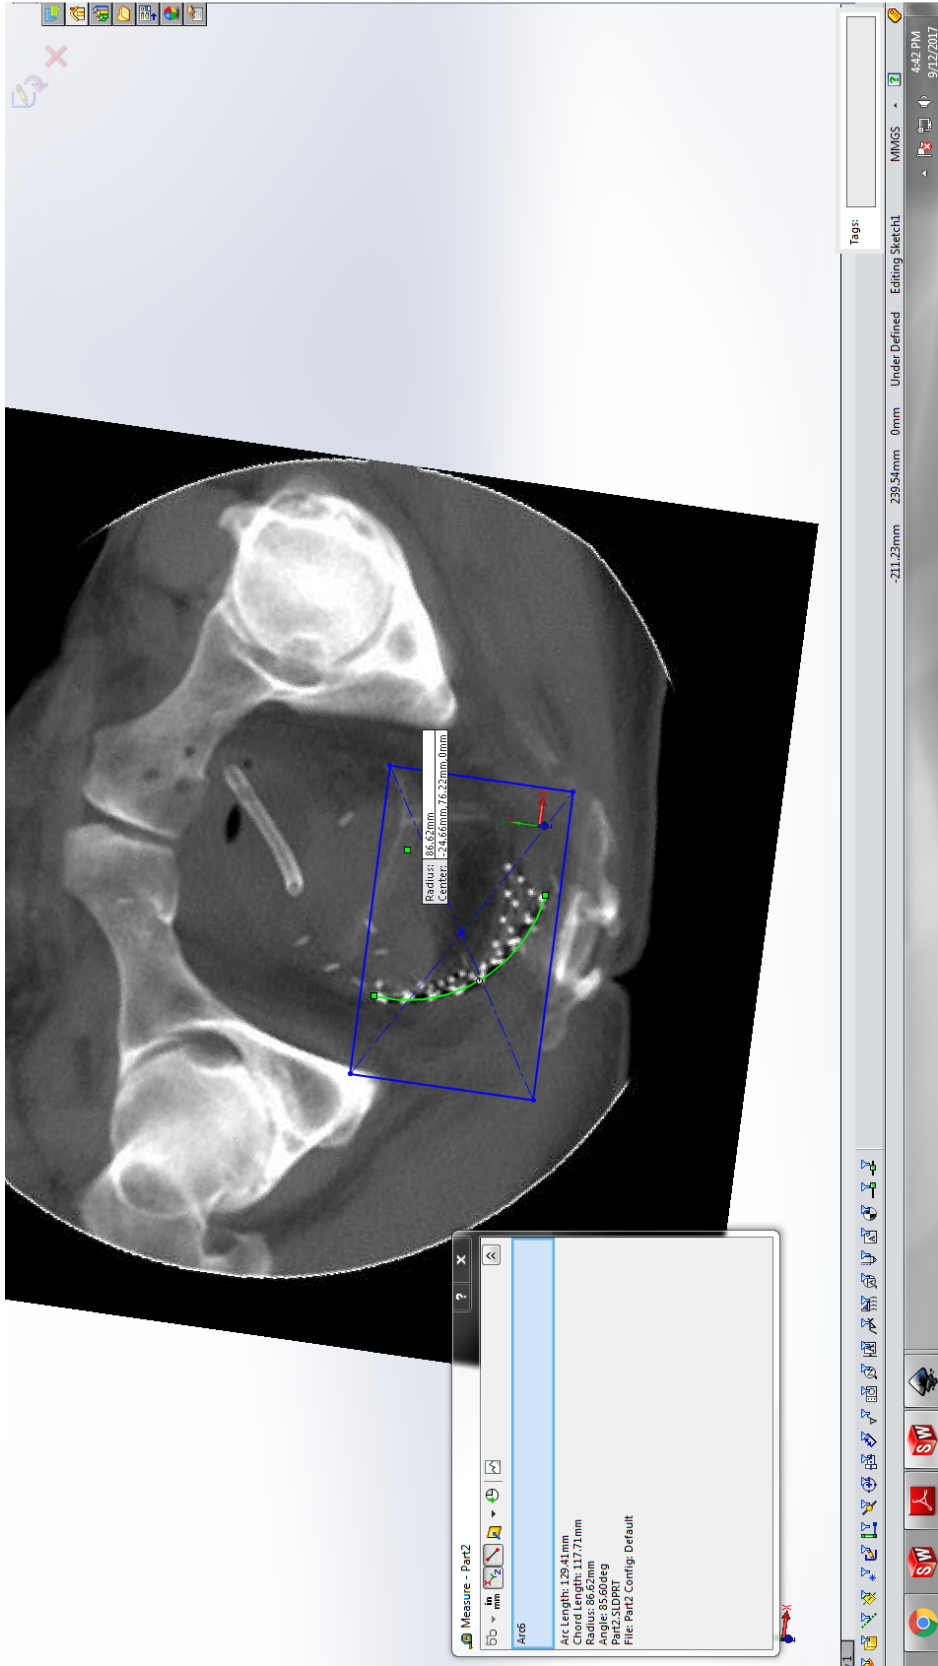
An acquired computed tomography image of a CivaSheet patient implant. Taking into account the scaling factor for the CT image, the radius of CivaSheet curvature for this implant was estimated to be 48 mm. [Imaged reproduced from personal communication, CivaTech Oncology Inc.]
